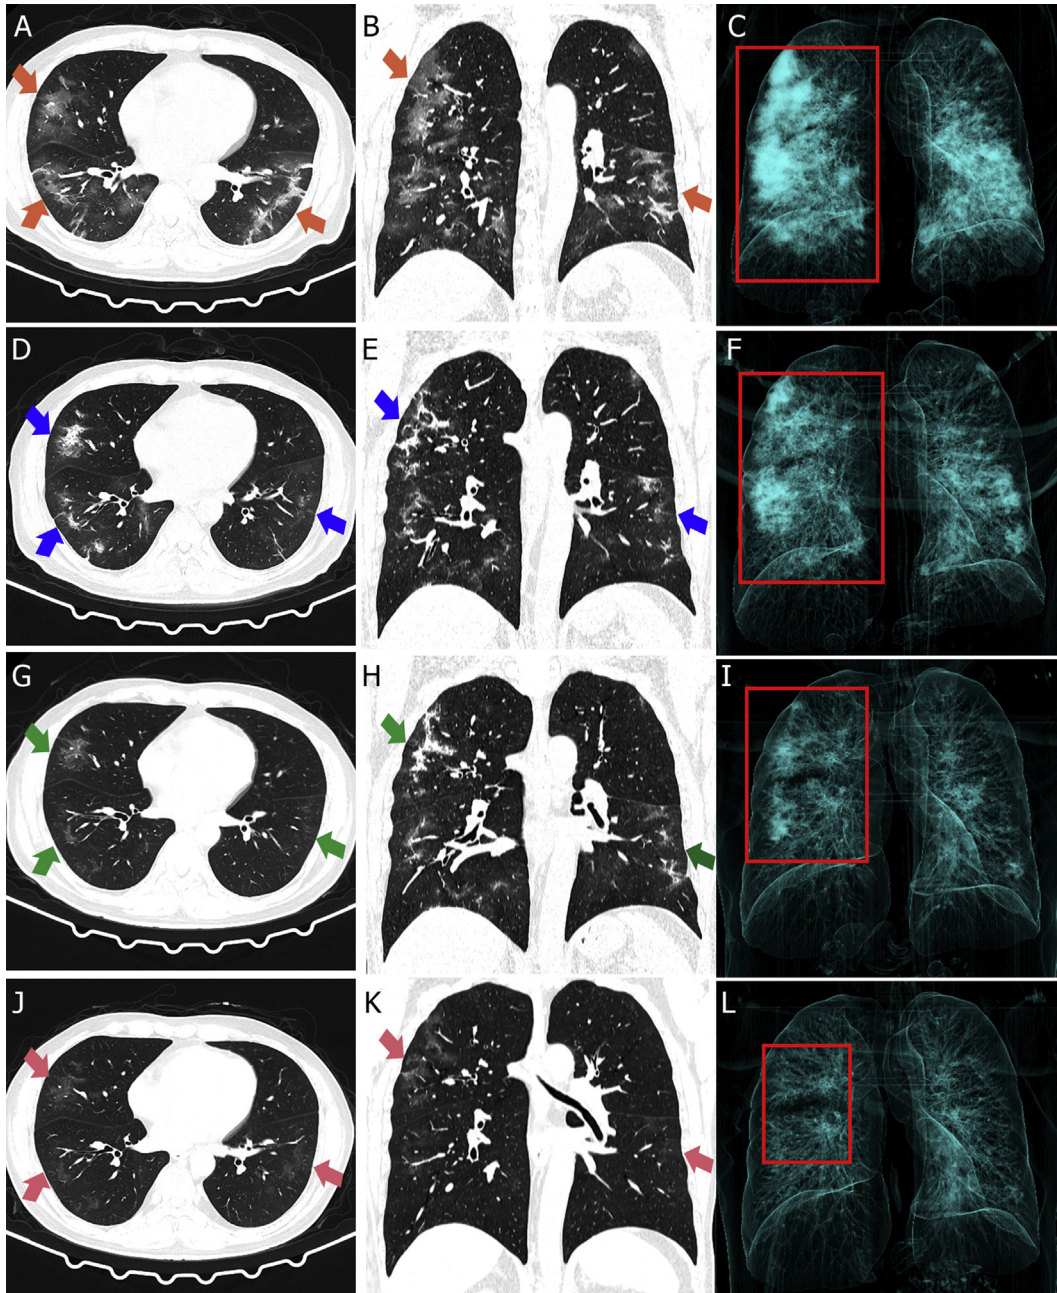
Time course of chest computed tomographic (CT) scan findings in a 50-year-old patient with COVID-19 (A–F, before discharge; G–I, after discharge; J–L, rehospitalized; and first column, axis scans; second column, coronal scans; third column, three-dimensional reconstruction). (C) Illness day 10 CT images revealed sporadic bilateral patchy ground-glass opacification with air bronchogram sign (orange arrows). Adjacent pleura was thickened without pleural fluid. (D–F) Illness day 16 (at hospital discharge) images showed increase of ground-glass opacities with a higher density and fiber stripes (blue arrows). (G–I) At 18 days' follow-up after discharge (illness day 34), reverse transcriptase PCR indicated positive again, while CT findings showed improvement of original lesion with a few ground-glass opacities (green arrows). (J–L) Thirteen days after rehospitalization (illness day 47); red arrows indicate further improvement of original lesions.
